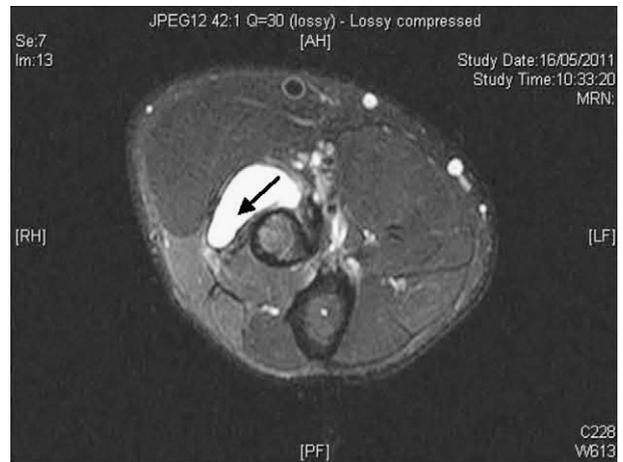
The MRI (T2 signal) showed a hyperintense cystic lesion (arrow) over the radial head region, adjacent to the neurovascular bundle.
